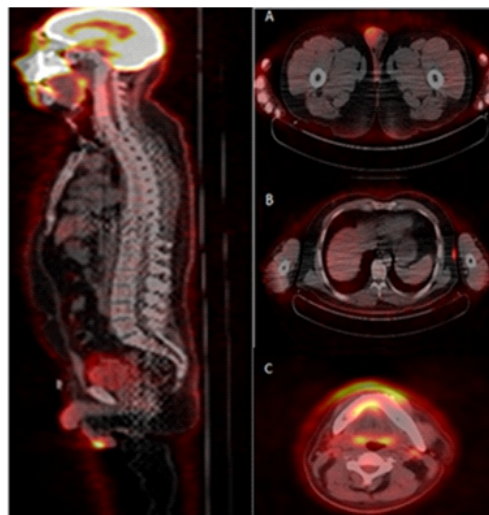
The image shows increased ^{18}F -FDG uptake in both nasal cavities, nasal septum, superior alveolar, upper gum © subcutaneous soft tissue nodules of the left chest wall, subcutaneous soft tissue of the left abdominal wall (B) and left testicle (A).
